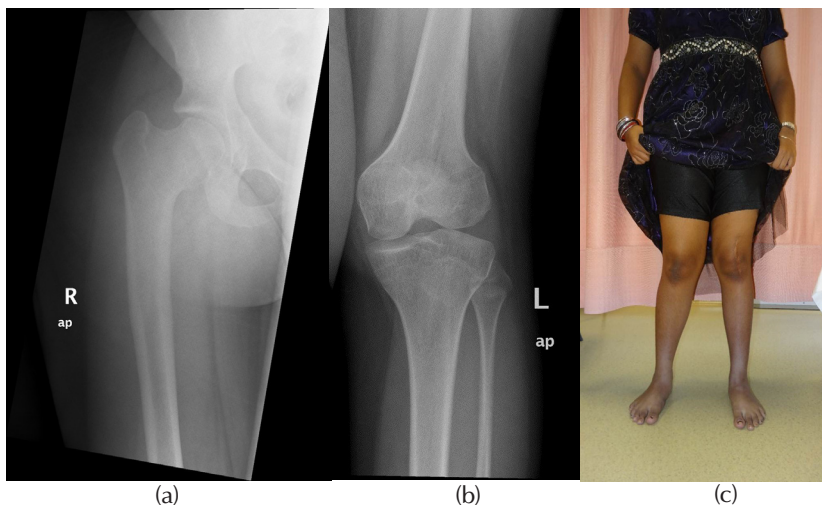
a) Radiograph of the hip after 11 years. The right femoral head healed with a coxa breva deformity; b) Radiograph showing the left knee femoral condyle had healed with minimal deformity after 11 years; c) Photograph of the asymptomatic child at the age of 13 years.
